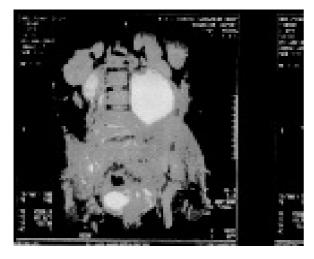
MRI of lower abdomen and sacroiliac joint showing caries spine involving lower dorsal, lumbar and sacral vertebrae along with involvement of the iliac bone with large bilateral psoas abscesses and intraspinal pus and granulation tissue.
